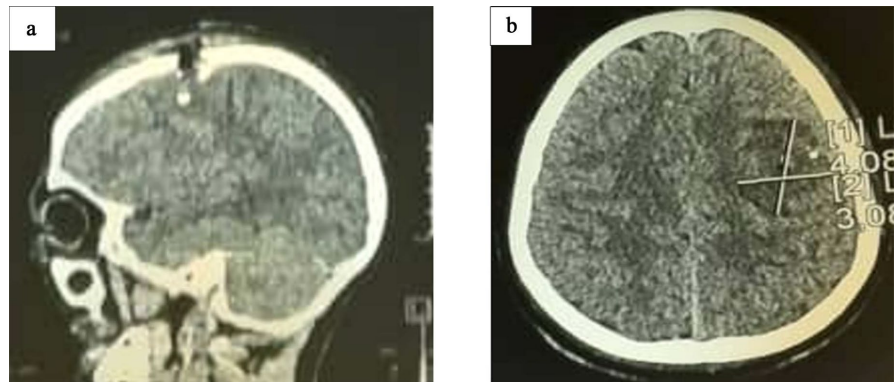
Non contrast cerebral CT-scan showing some outbreaks of oedemato-hemorrhagic contusions with intraparenchymal bone debris along the path of the bar and a small right fronto-parietal acute subdural hematoma (a); Brain CT-scan with injection of contrast material performed one week after the trauma showing an extended brain abscess along the path of the bar (b).
